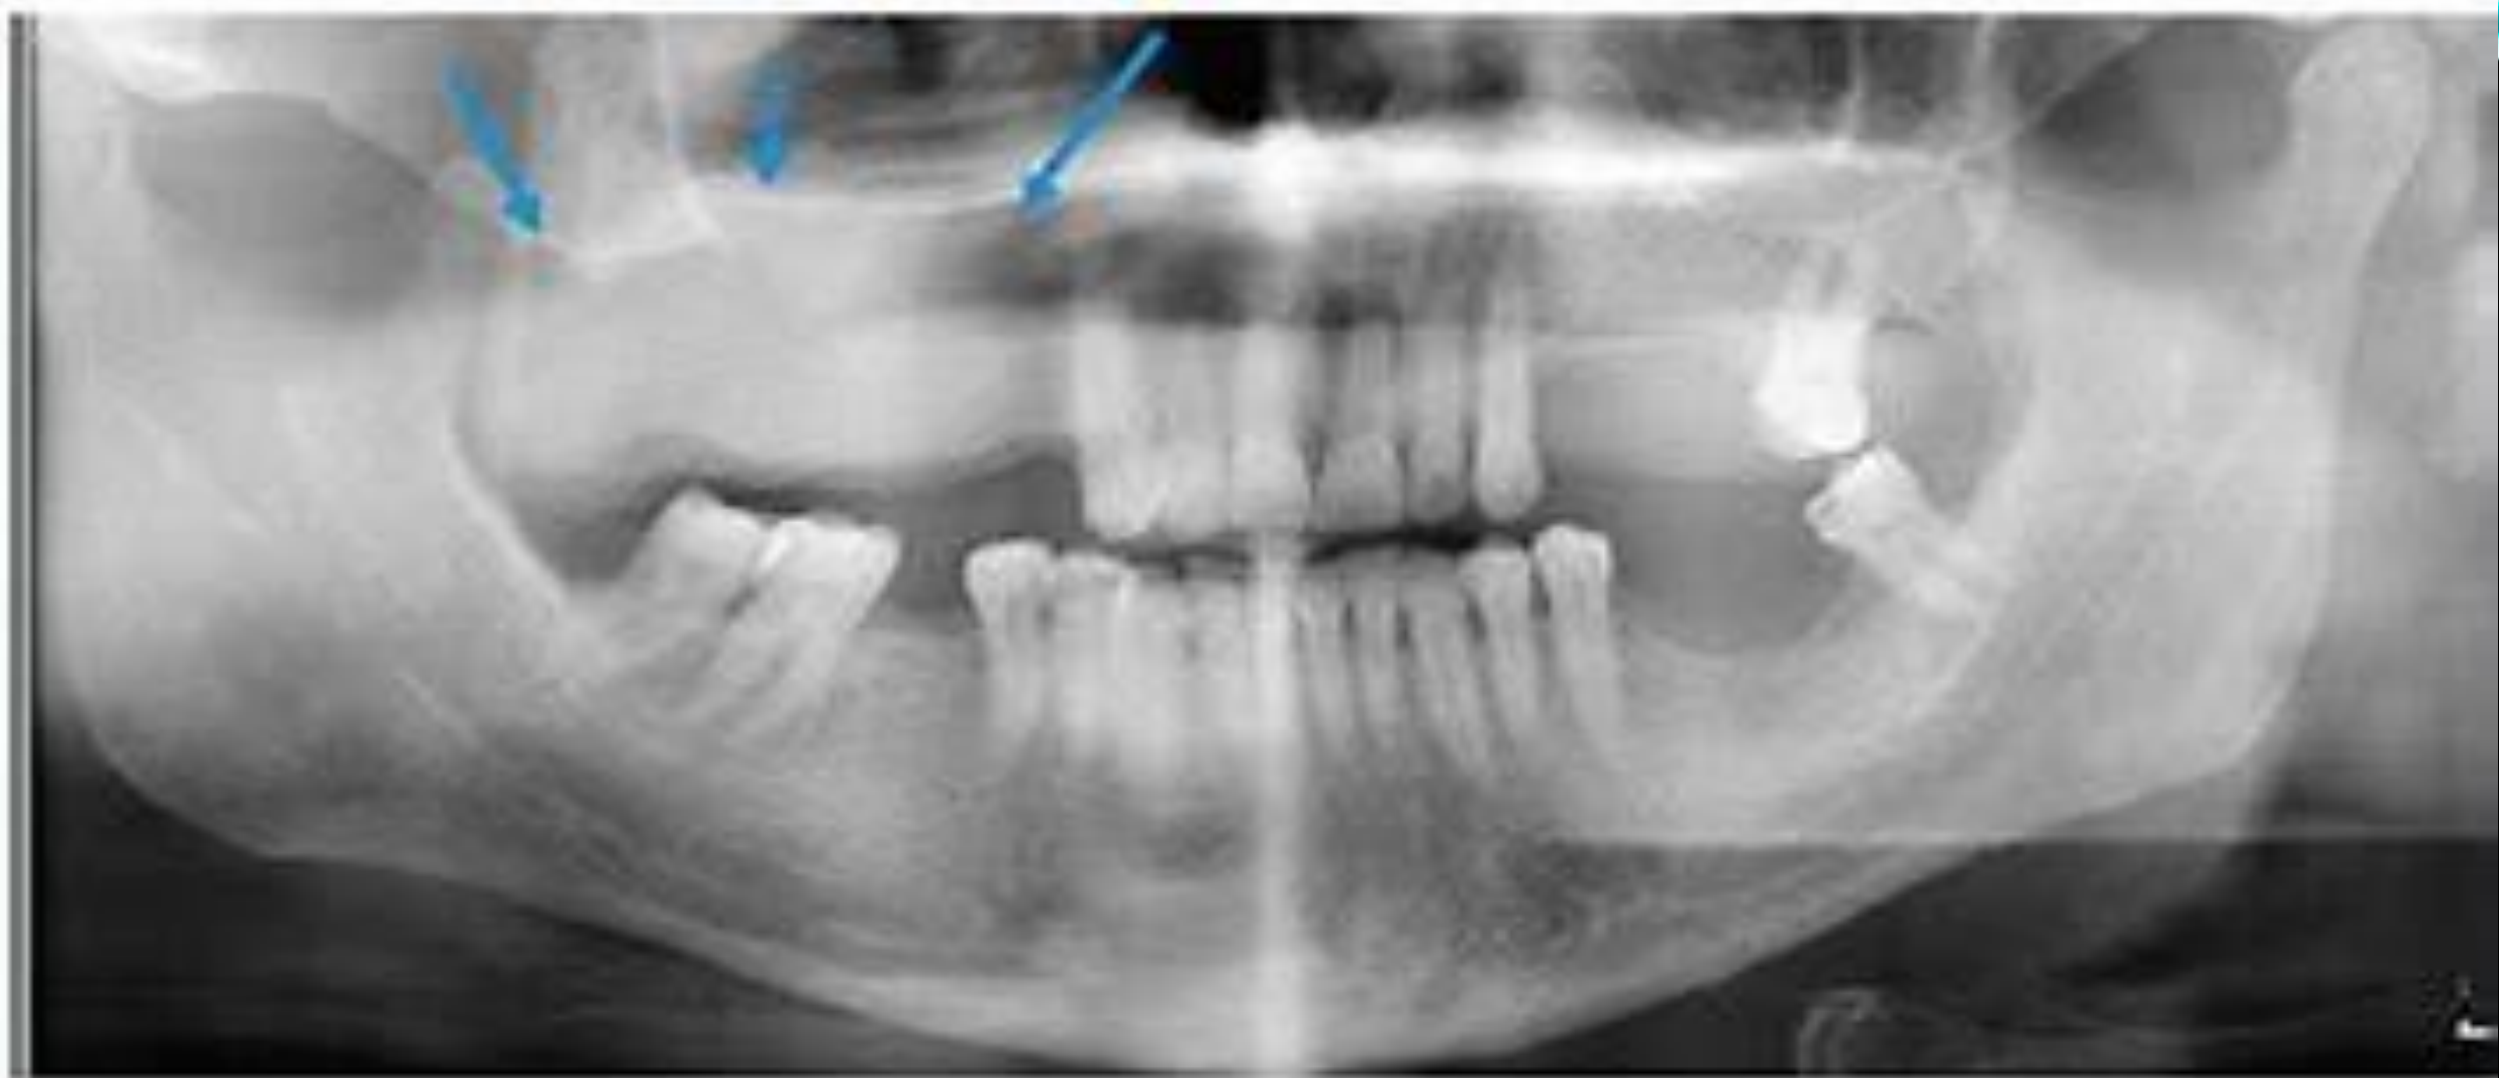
Panoramic radiograph, diffuse granular appearance known as a "ground glass" appearance and expansion
